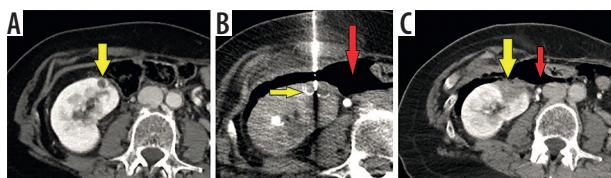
Radiofrequency ablation (RFA) of a renal cell carcinoma of the right kidney, A) pre-treatment CT scan of the right kidney with upper pole small renal mass (yellow arrow), B) CT scan of RFA probe (yellow arrow) with artificial pneumoperitoneum (red arrow) to displace the colon to avoid bowel necrosis/perforation, C) posttreatment CT scan immediately after RFA with complete necrosis of the ablation zone and tumour (yellow arrow) and the artificial pneumoperitoneum
